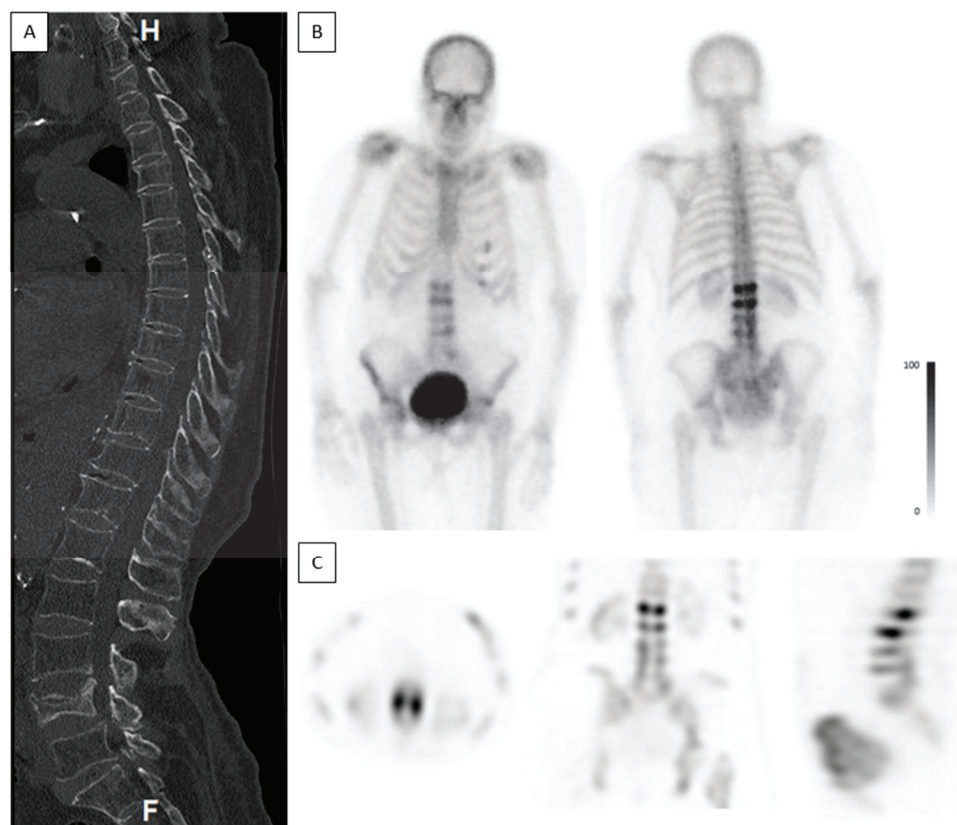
Occult fractures. A 78-year-old female complaining of back pain, without known trauma. CT was acquired on the day of admission and bone scintigraphy was performed 2 days after the CT. (A)—Sagittal spine CT shows a non-union fracture in L4. No other fractures are demonstrated. Bone density measured in L3 was 7 HUs, consistent with severe osteoporosis. (B)—Planar anterior and posterior bone scintigraphy shows high-intensity uptake in L2 and L3, suggestive of acute fractures. (C)—Axial, coronal, and sagittal SPECT show high-intensity uptake in L2 and L3.
